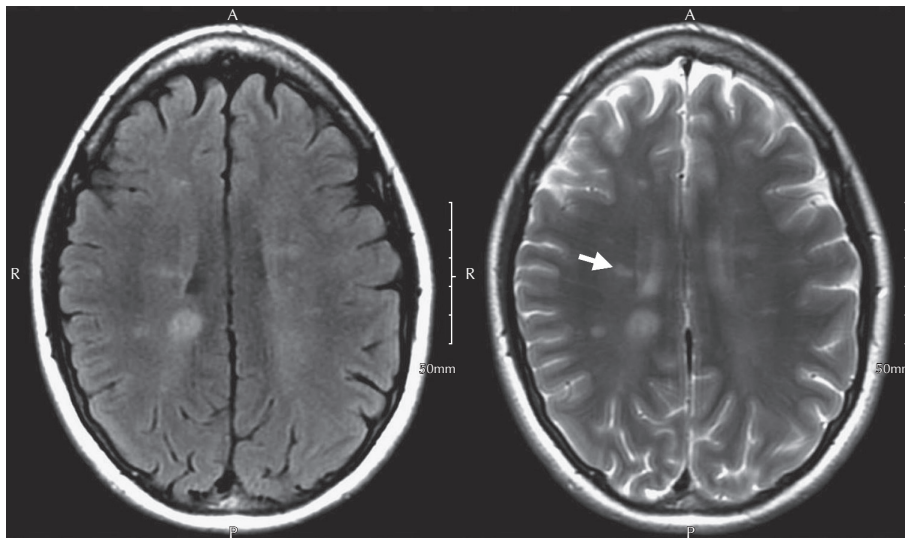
FLAIR and T2W axial images demonstrate multiple deep white matter hyperintensities. Note the radial pattern to many of these lesions, indicated by the arrowhead.
